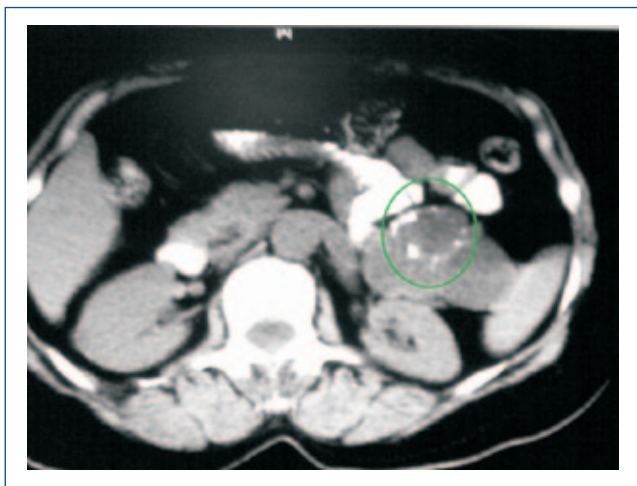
Evidence of neoplasia in the second patient. CT scan of the abdomen of the second patient shows a cystic lesion in the body and tail of the pancreas, with internal septa and calcification (green circle), features suggestive of cystic neoplasia. Other features include thick wall, internal septa, mural nodules, papillary projections, solid components, lobulated margins, and cyst complexity with solid components (not shown here).
